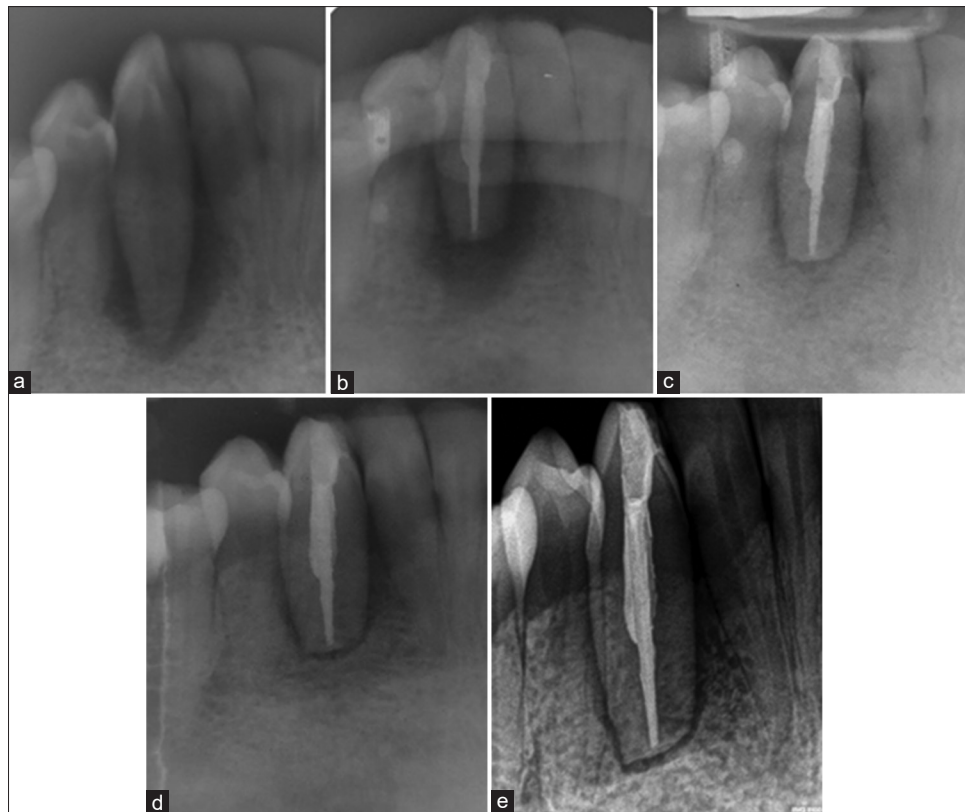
Radiographic evaluation: (a) Radiovisiography 43 region– baseline, (b) Radiovisiography 43 region– 1 month, (c) Radiovisiography 43 region– 3 months, (d) Radiovisiography 43 region–9 months, (e) Radiovisiography 43 region– 12 months
